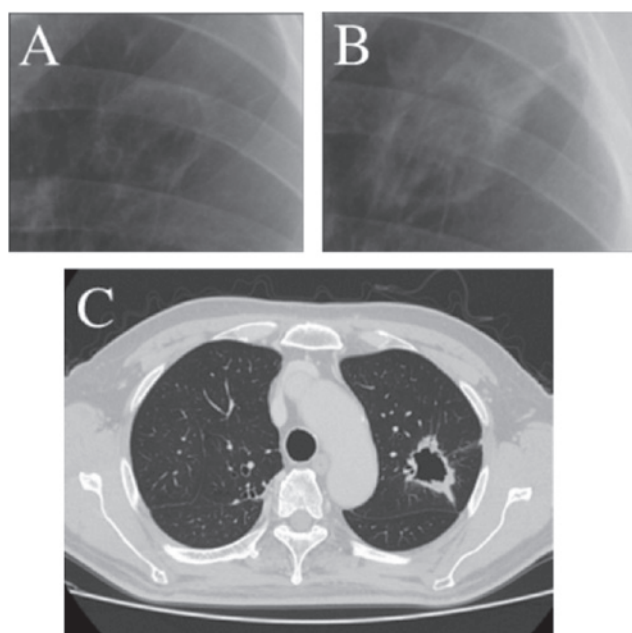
Chest X-ray findings. (A and B) The wall of the cystic lesion in the left lung upper field (B) was thicker compared with that 3 years earlier (A). (C) Computed tomography scan of the lesion. A solid, irregularly margined tumor surrounding a cavitary lesion was identified in the upper lobe of the left lung. The greatest diameter of the tumor was 35 mm and the thickness of the cavity wall was 9 mm.
